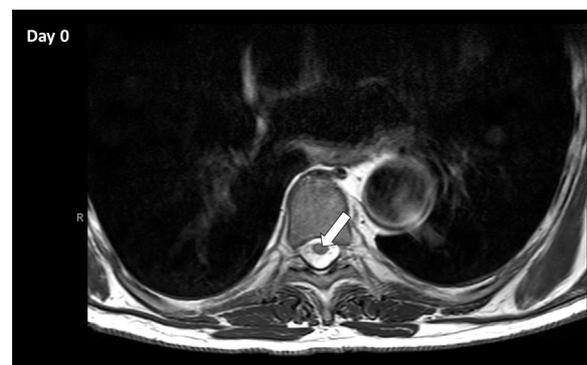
T2 weighted magnetic resonance imaging (axial view) of the thoracic spine on day 0 demonstrating no signs of spinal cord ischemia (arrow) or compression.
